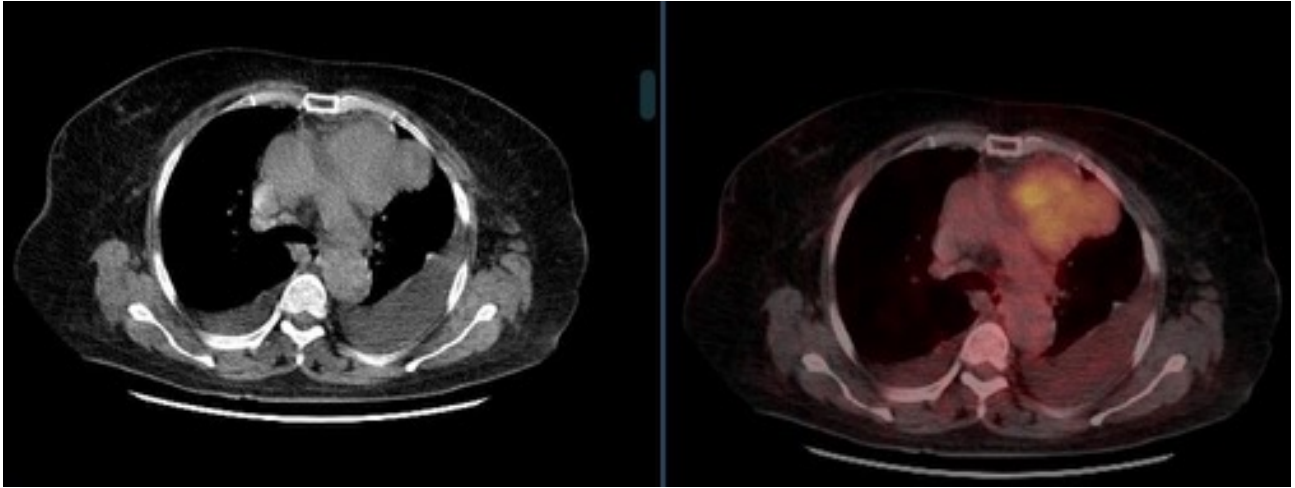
PET/CT images of an anterior mediastinal mass case diagnosed via VATS.
